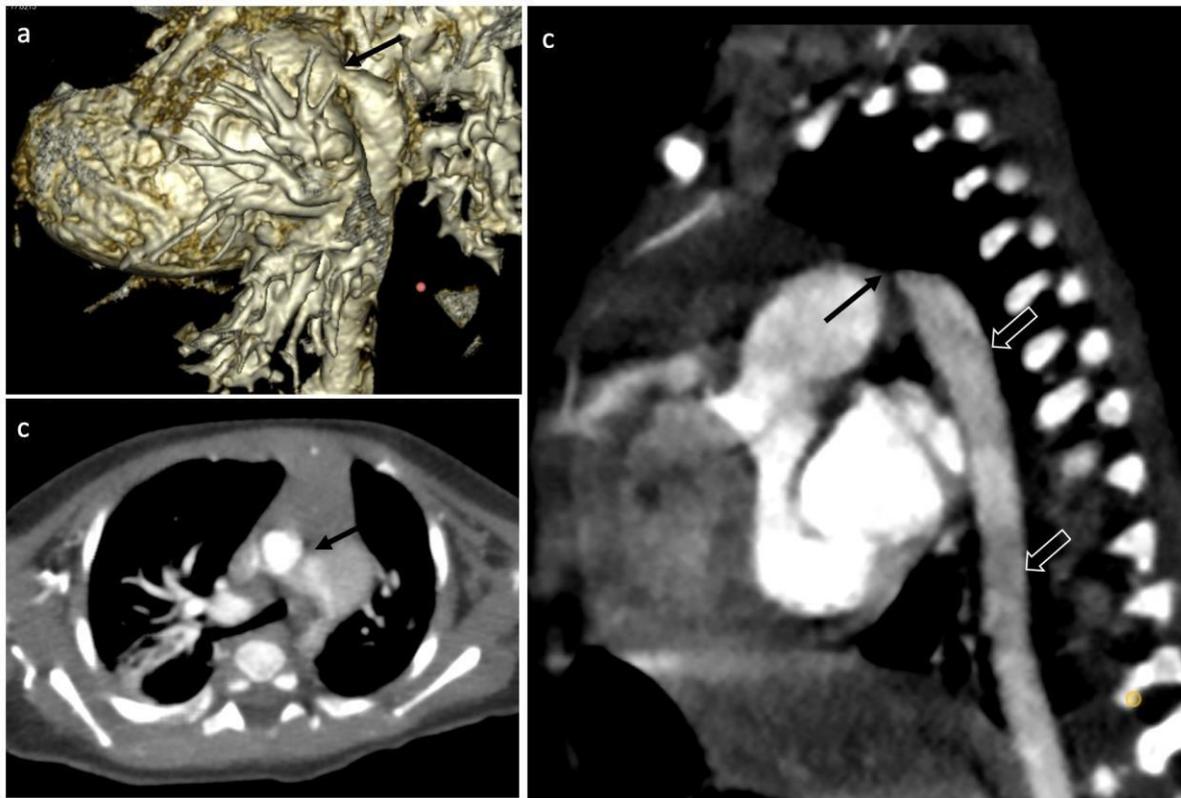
CTA of baby boy 4-month-old, (a) PDA, the connection between the descending aorta and left pulmonary artery (calibre of 0.5 cm) at the 3D image, which is confirmed with the axial image (c), (b) coronal section, shows an interrupted aortic arch (IAA), no arch aortic finding, and the size and shape of the abdominal aorta is normal.
